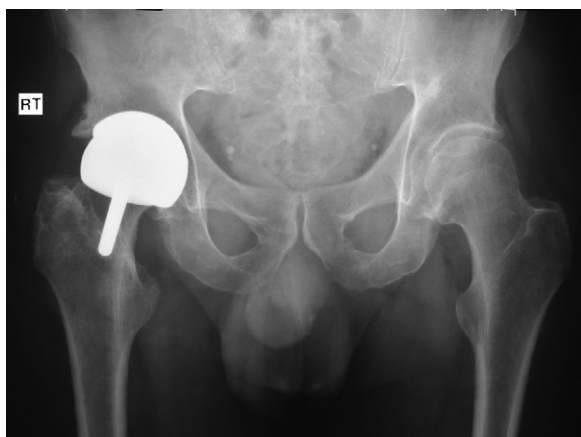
Patient 2 radiograph AP pelvis (United).
